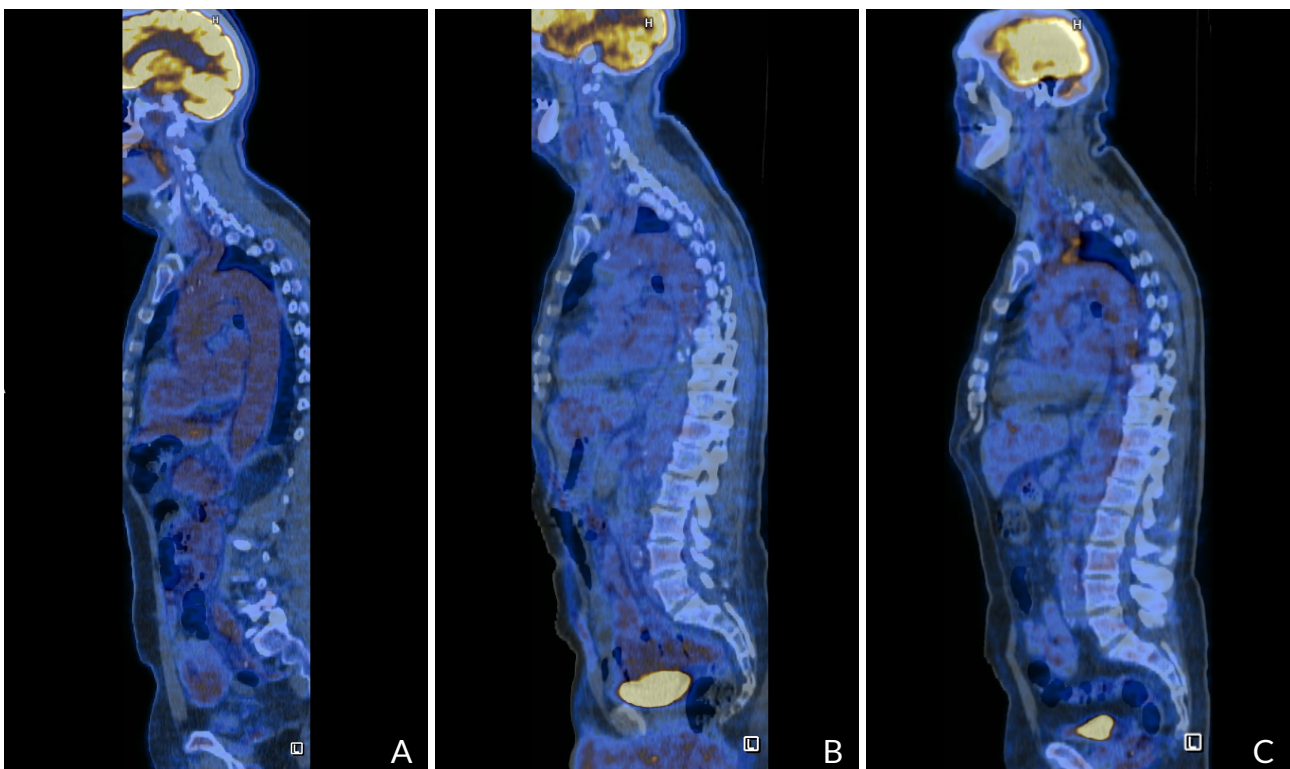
A) FDG-PET/CT scan before initiated treatment suggesting active vasculitis. B) FDG-PET/CT scan 6 months after initiated treatment with corticosteroids, doxycycline and hydroxychloroquine indicating diminished inflammation. C) FDG-PET/CT scan after finishing treatment with doxycycline and hydroxychloroquine and reducing dosage of corticosteroids, demonstrating extended vasculitis.
